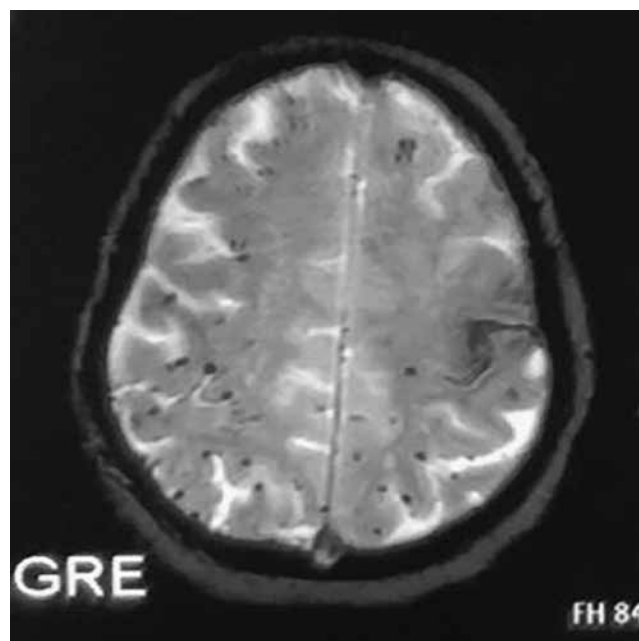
MRI brain GRE sequence showing multiple cortical/subcortical hemorrhages in bilateral cerebral hemispheres.
